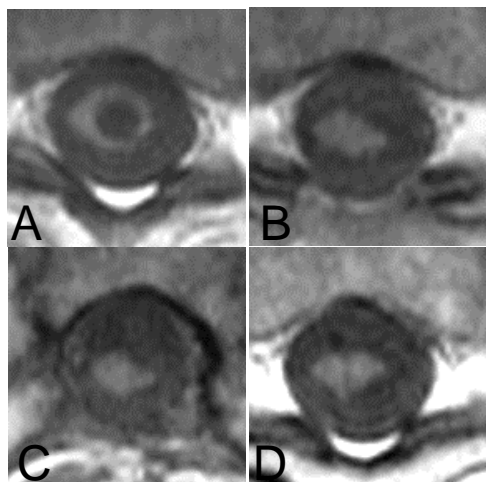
Axial T1-weighted MR images through the graft site in Subject 6 at 2 weeks pre-operative (A), 3 months (B), 12 months (C), and 24 months (D) postgrafting.
